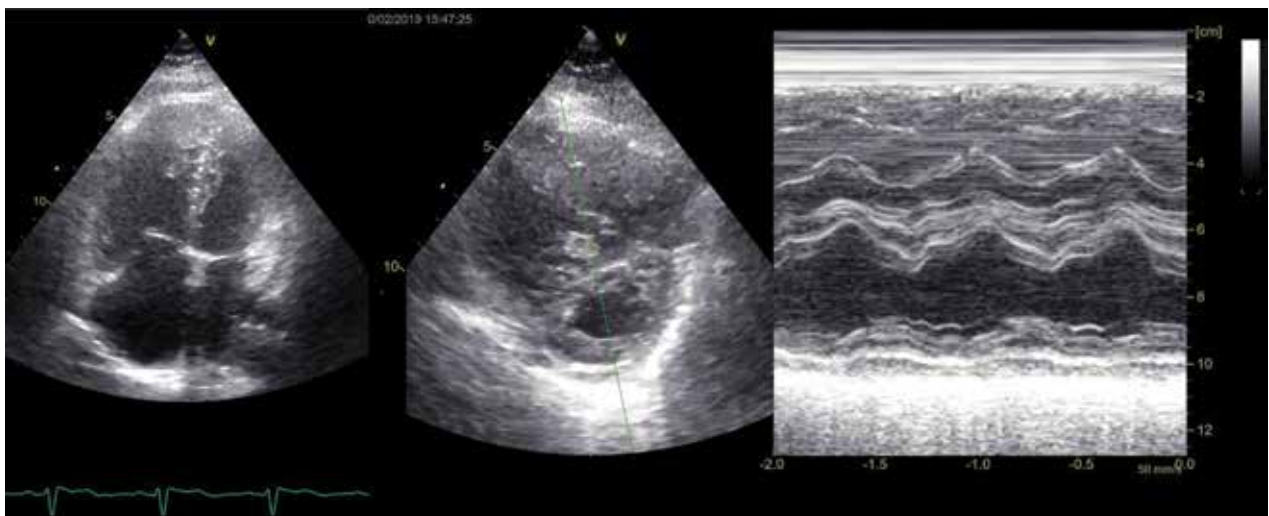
2D Echocardiographic RV size in apical 4 chamber plane showing LV/RV ratio < 1 and short axis showing D shaped LV
